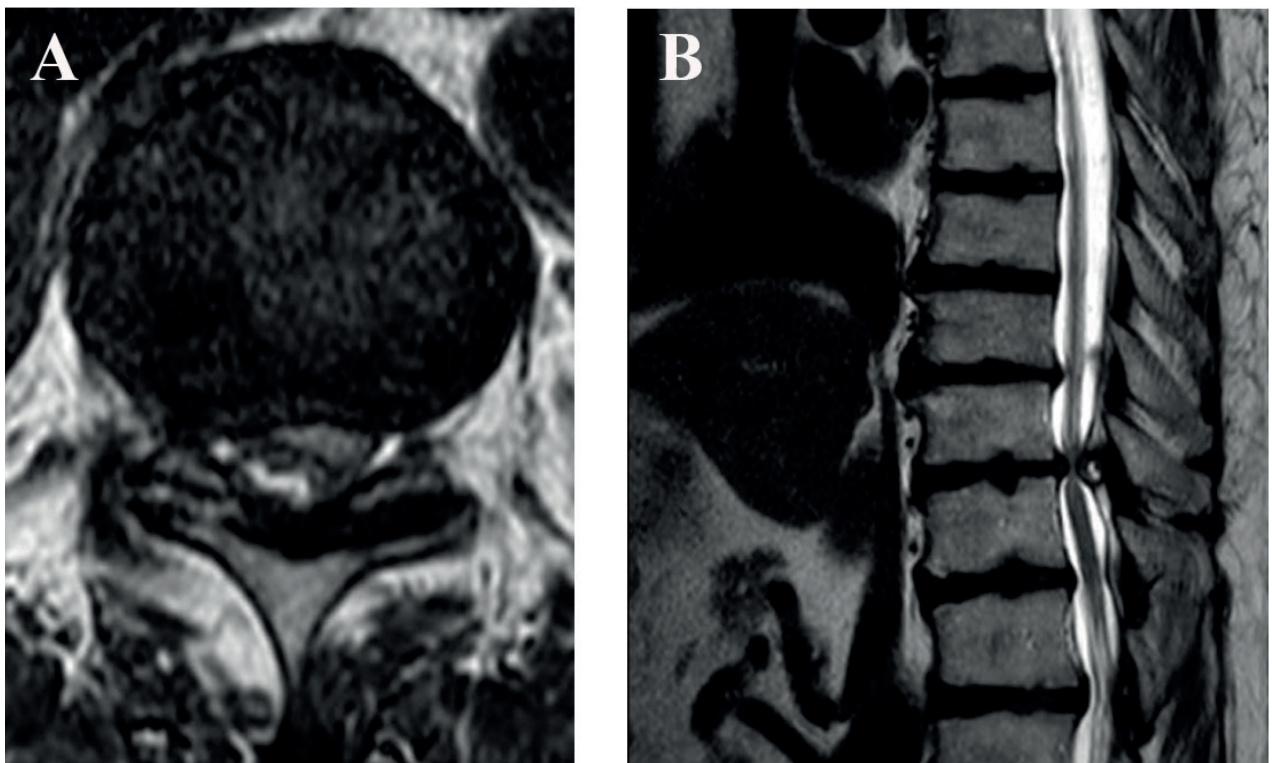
Preoperative T2-weighted axial (A) and sagittal (B) MRI of the thoraco-lumbar spine, showing the cystic lesion. In these sequences could be seen the hyperintense central component of the cyst.
